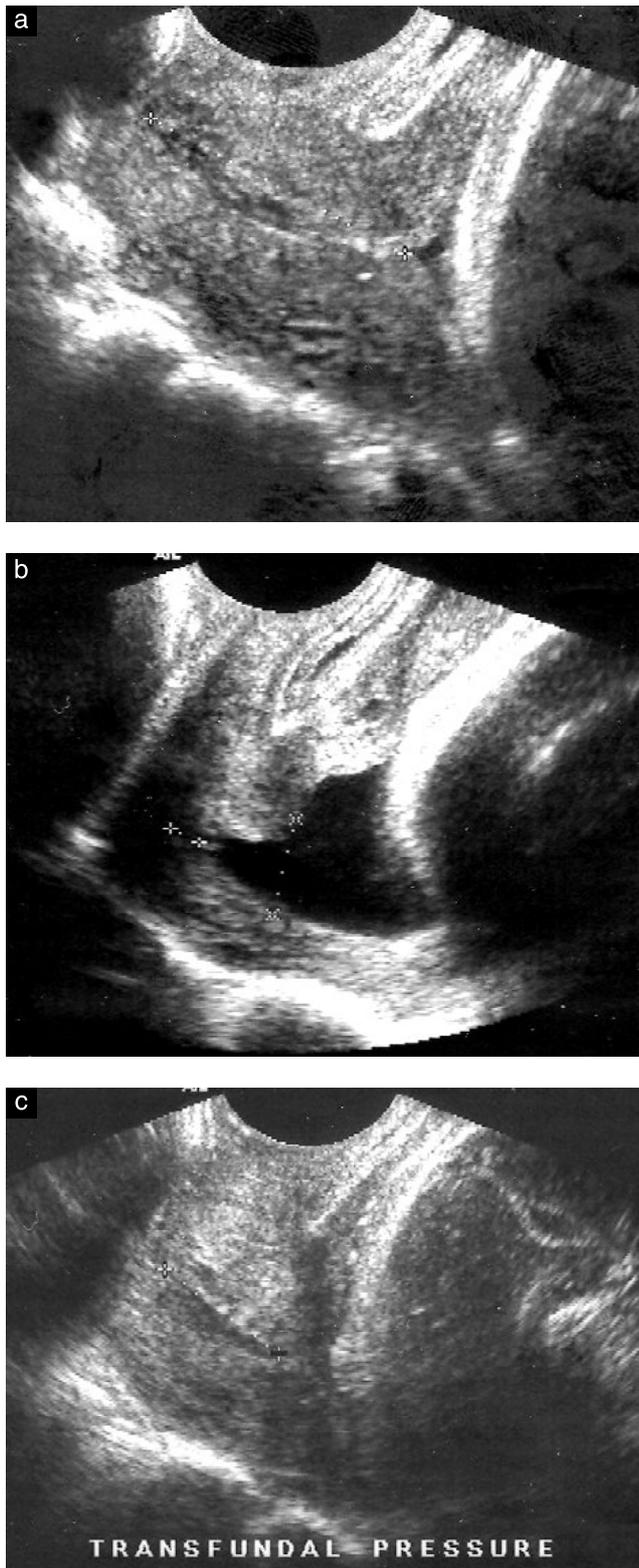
Transvaginal sonography of the cervix within one patient; a) cervix in the recumbent position, b) cervix in the upright position (after 1 min), c) cervix with transfundal pressure.
